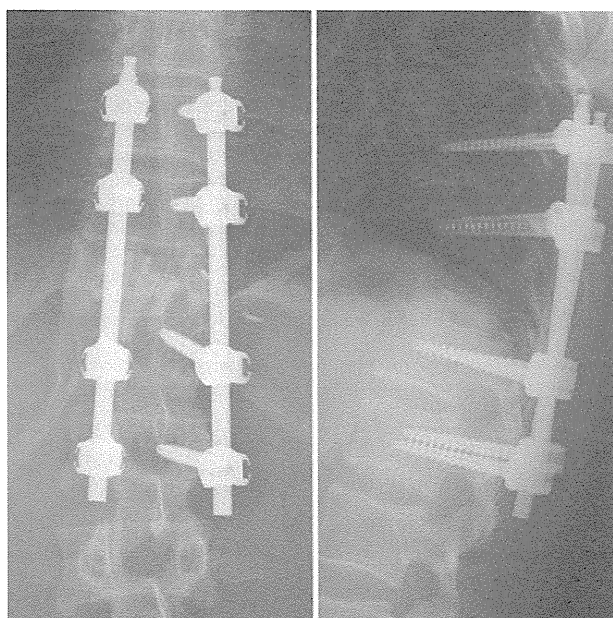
Postoperative (15 months) plain radiographs showing a slight loss of reduction in local kyphosis.
